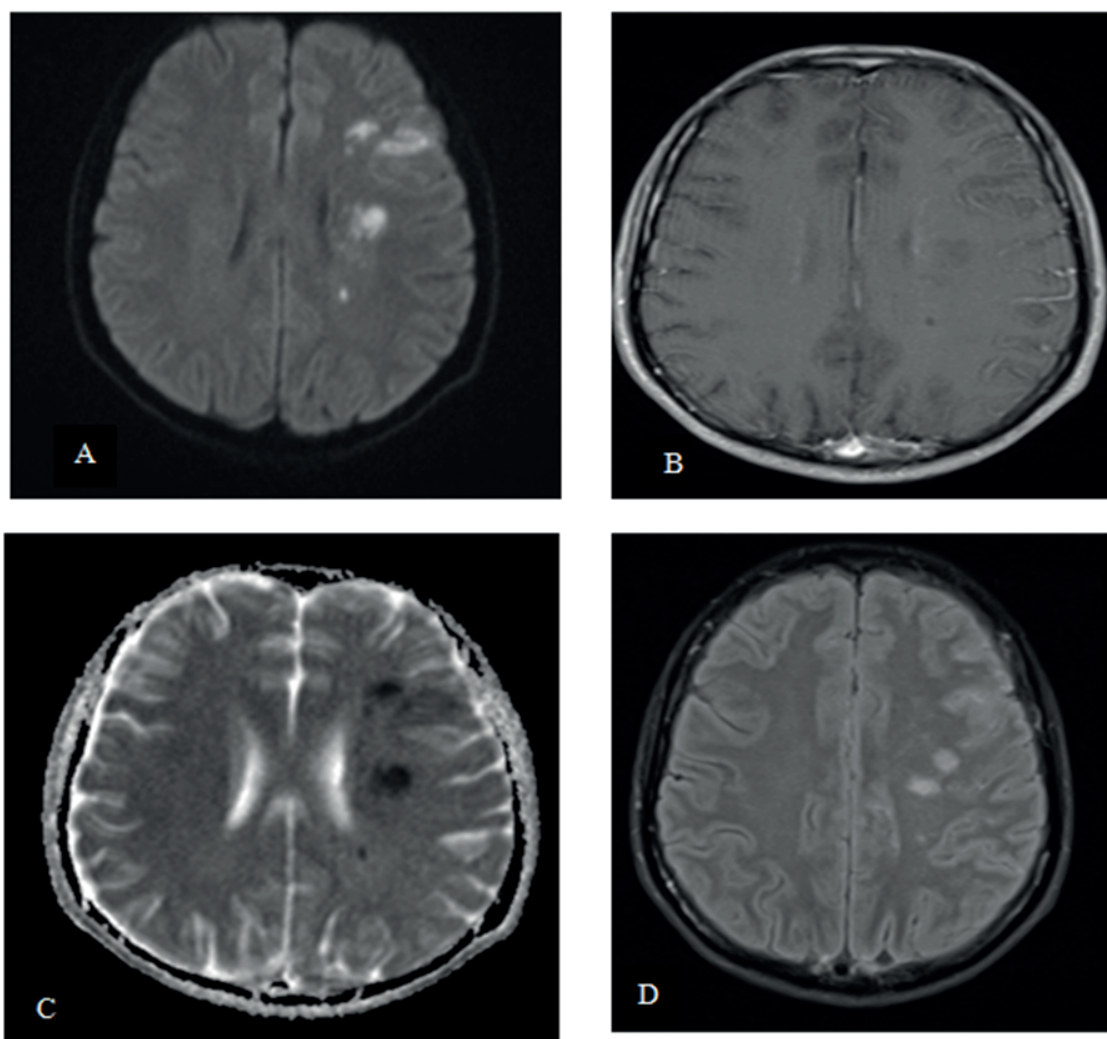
MRI performed at presentation of neurological deficit.
